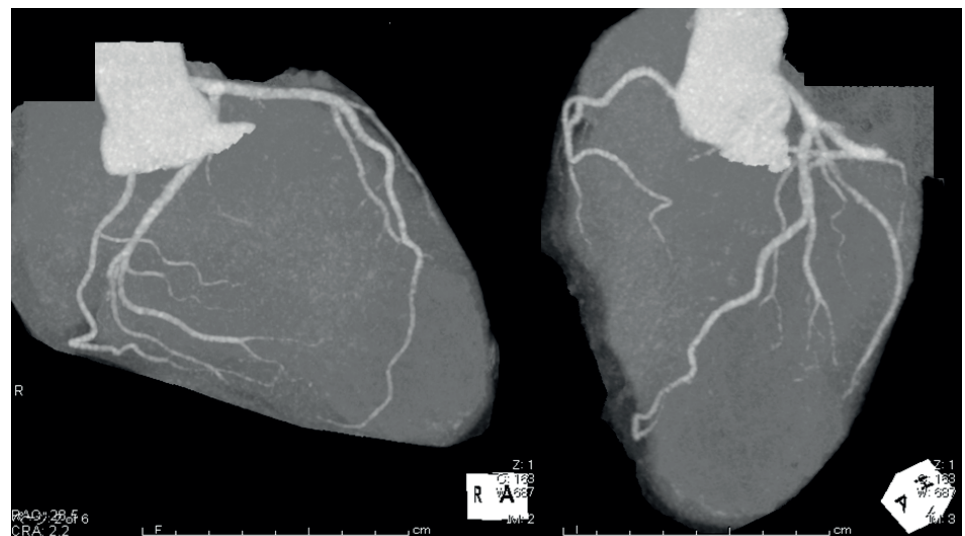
Coronary CTA. This image shows normal coronary arteries. CTA = computed tomography angiography.
